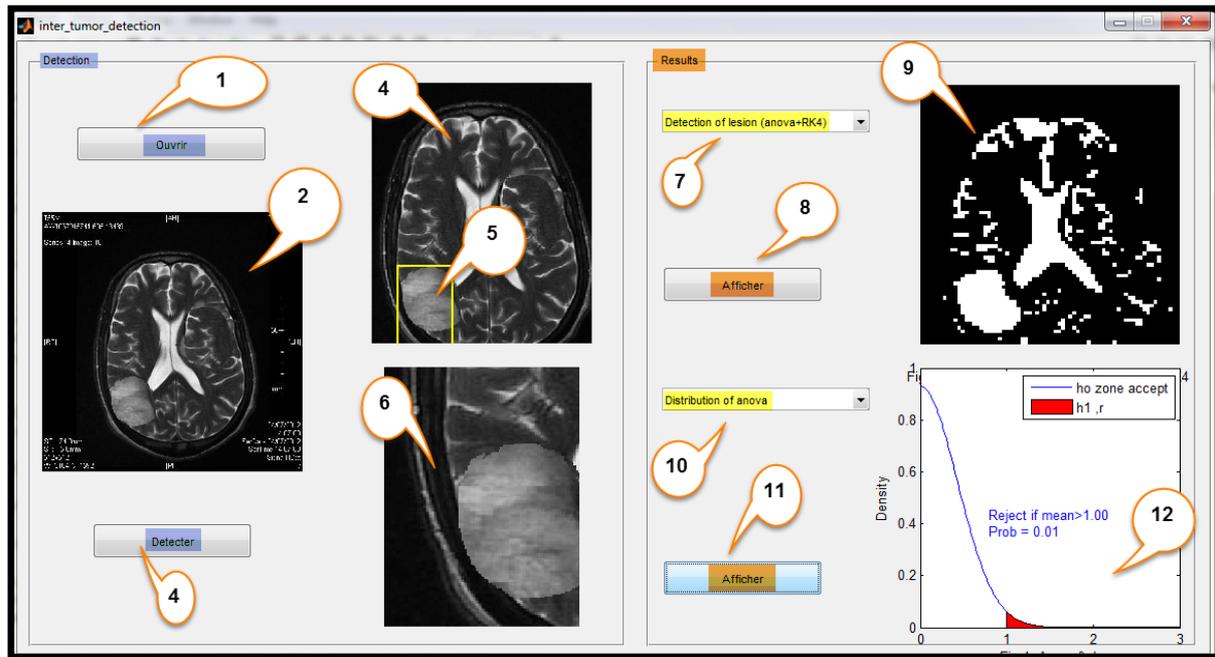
(b) Interface system for different MRI sample with tumor on the left side
